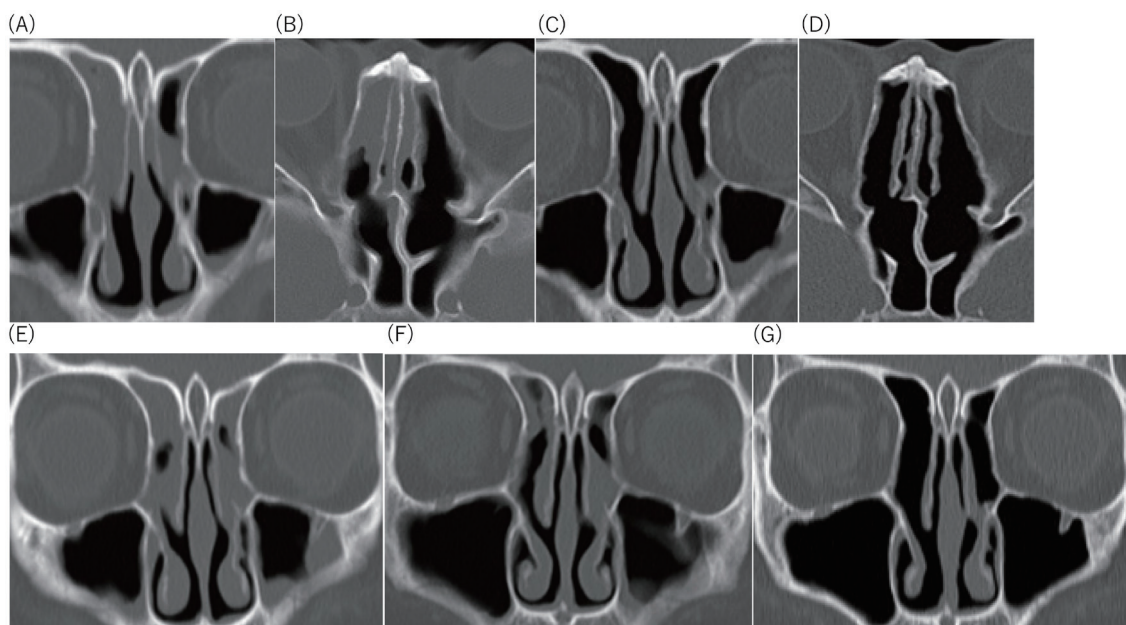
Changes in CT imaging findings during biologic therapy. Coronal (A) and axial (B) CT images before dupilumab initiation; coronal (C) and axial (D) CT images after 2 doses of 300 mg dupilumab; coronal CT image after 2 cycles of mepolizumab and dupilumab (E); coronal CT image 13 months after starting treatment (four cycles of the combination therapy) (F); and coronal CT image 19 months after starting treatment (6 cycles of the combination therapy) (G).
